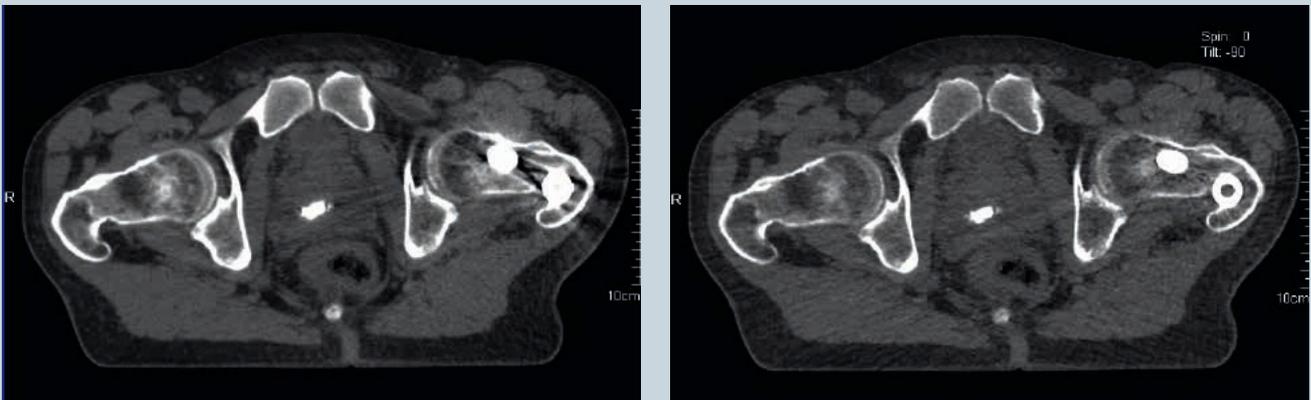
Left: Standard 120 kV CT scan of the left femur for RT planning. Right: 120 keV DE Monoenergetic image with a clear reduction of streak artifacts in the region of the target volume (left femur).
